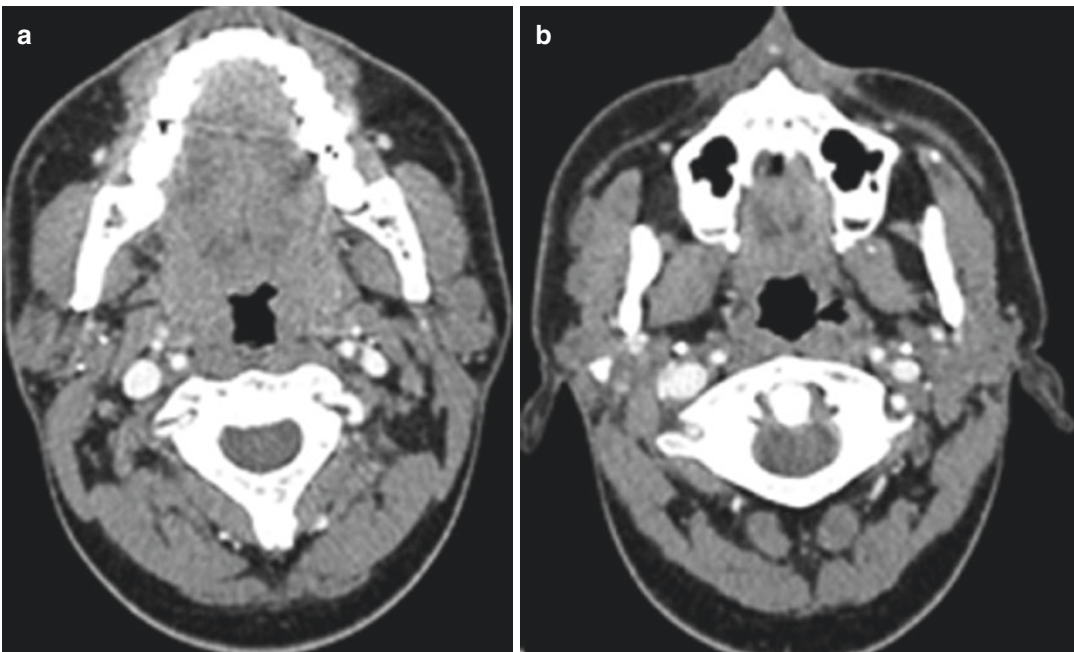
CT demonstrating persistent right parotid stone with additional punctate parotid stones
